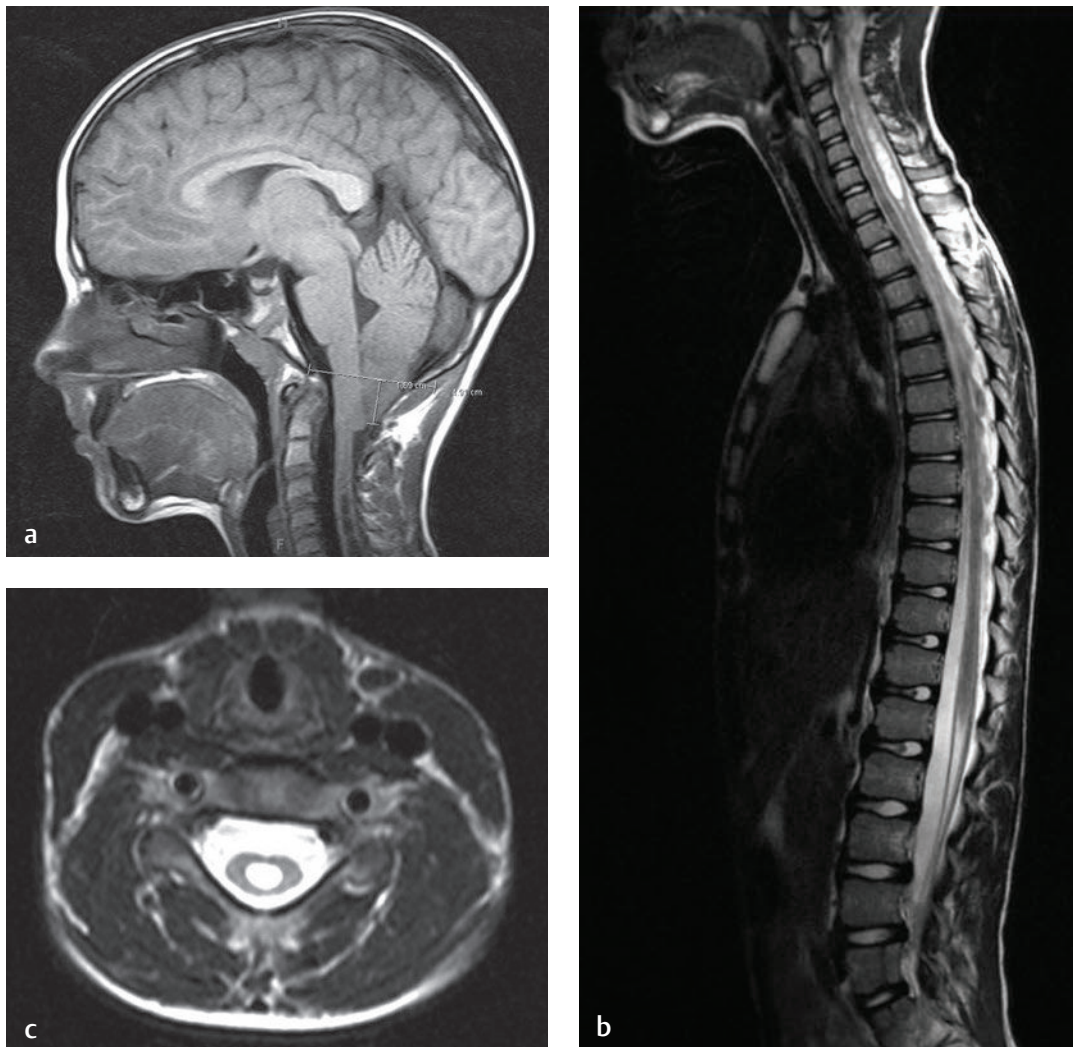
A 9-year-old boy with a large syrinx of the cervical spine. (a) A sagittal T1-weighted image of the brain and upper cervical spine showing an Arnold Chiari type-I malformation and a syrinx of the upper cervical spine (lines showing 4.91 cm of cerebellar tonsil ectopia below the level of the foramen magnum). (b) A sagittal T2-weighted image of the entire spine showing a large syrinx extending from C4-C7. (c) An axial T2-weighted image at the C6 level confirms that the syrinx is located in the center of the spinal cord.
